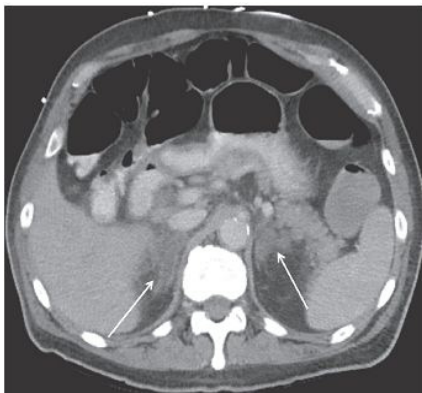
Contrast enhanced CT shows bilateral adrenal gland enlargement with central hypo enhancement.
